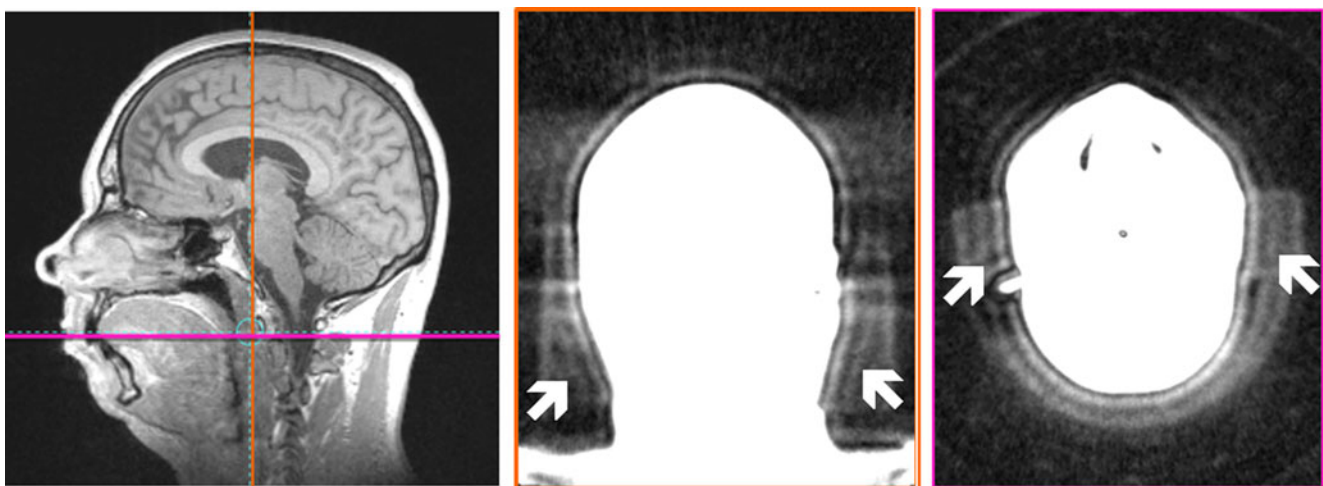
Ultrashort echo time (UTE) MR imaging for visualizing extracorporeal structures such as immobilization devices. From left to right Sagittal scout, coronal and axial images from UTE acquisition (investigational UTE sequence with TE 0.07 ms, TR 3.56 ms, flip
